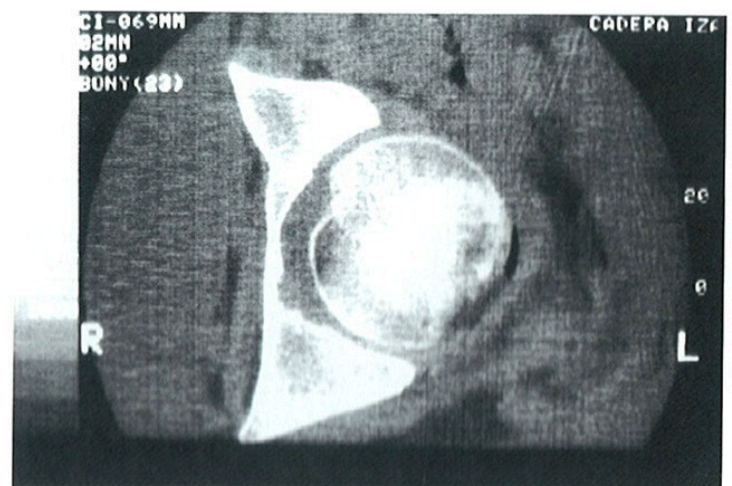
CT scan showing complete excision.
